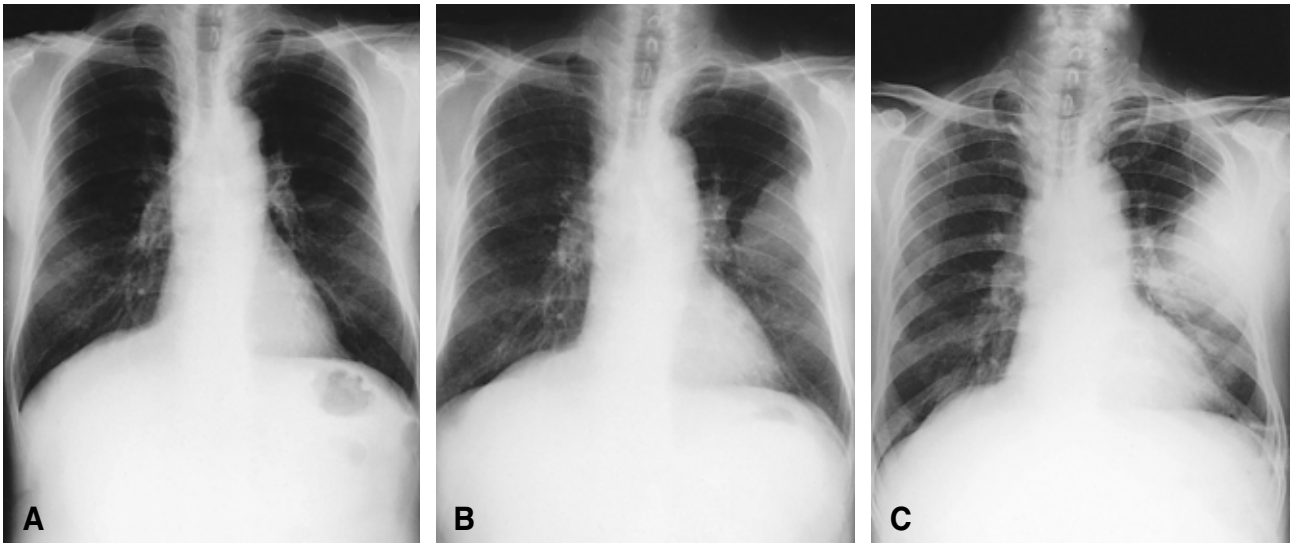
(A) Initial chest X-ray showing no abnormalities. (B) Chest X-ray showing chest wall metastasis with invading adjacent ribs after 3 months. (C) Chest X-ray showing growing chest wall mass compared to previous images.
